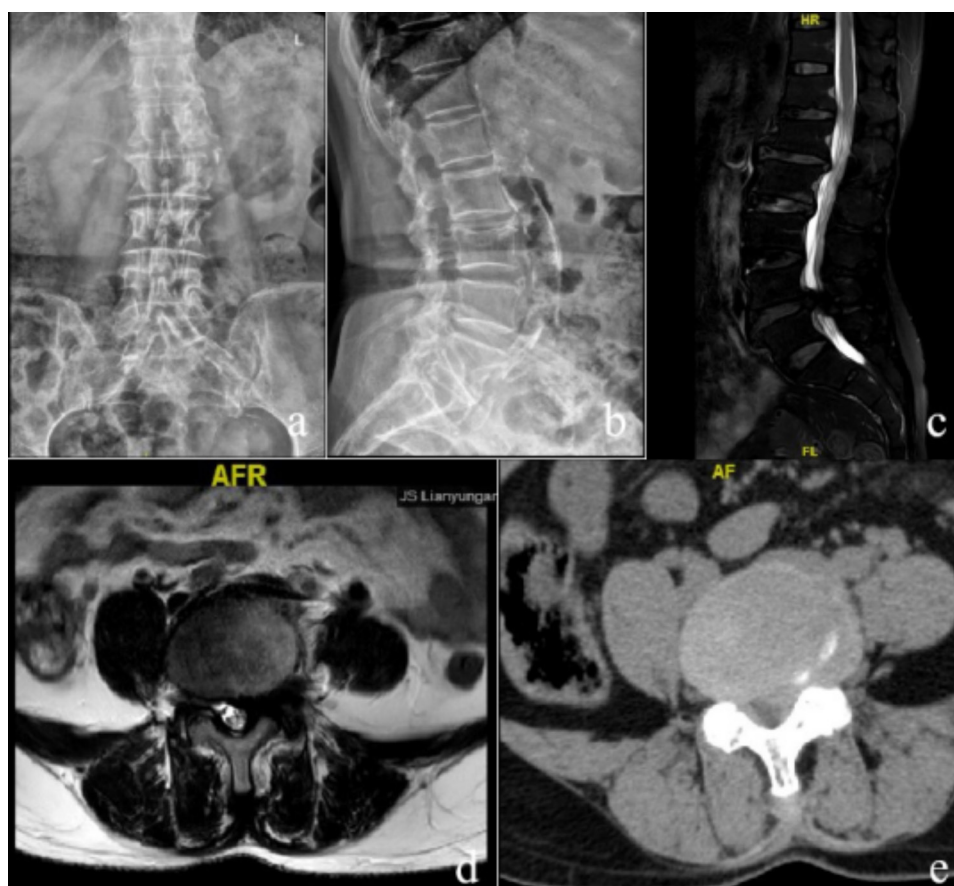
a-b, preoperative frontal and lateral radiographs of the lumbar spine showed degenerative changes in the lumbar spine. c-e, MRI and CT of the lumbar spine showed herniated and bulging L4/5 disc with lumbar spinal stenosis and compression of the dural sac by the herniated disc.
